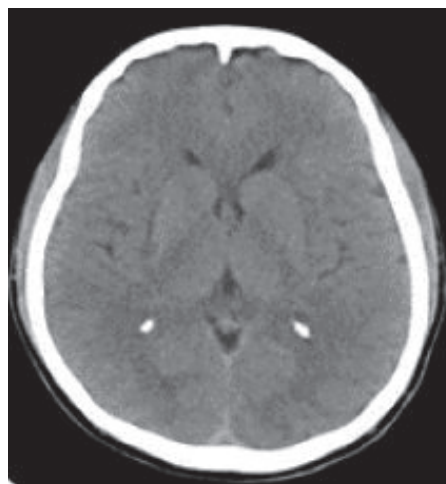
Normal CT scan of brain
